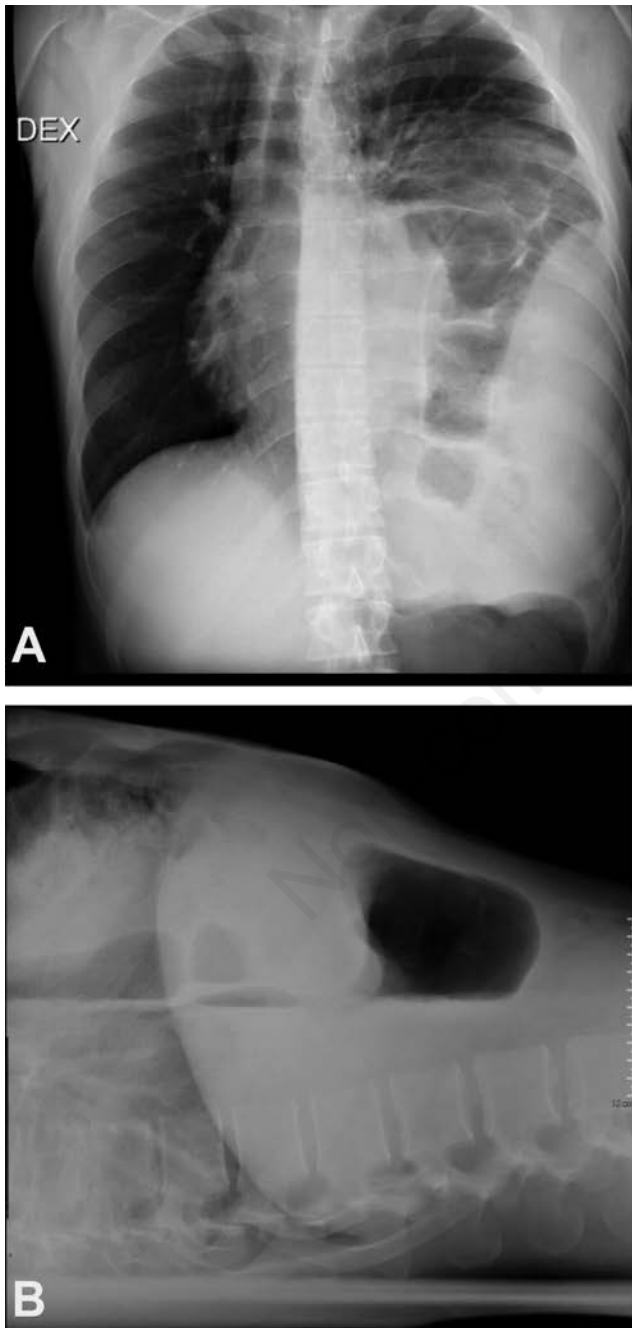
(A) Chest x-ray showing the presence of the bowel in the mediastinum; (B) Chest x-ray presence of gastric air bubble in the thorax.
